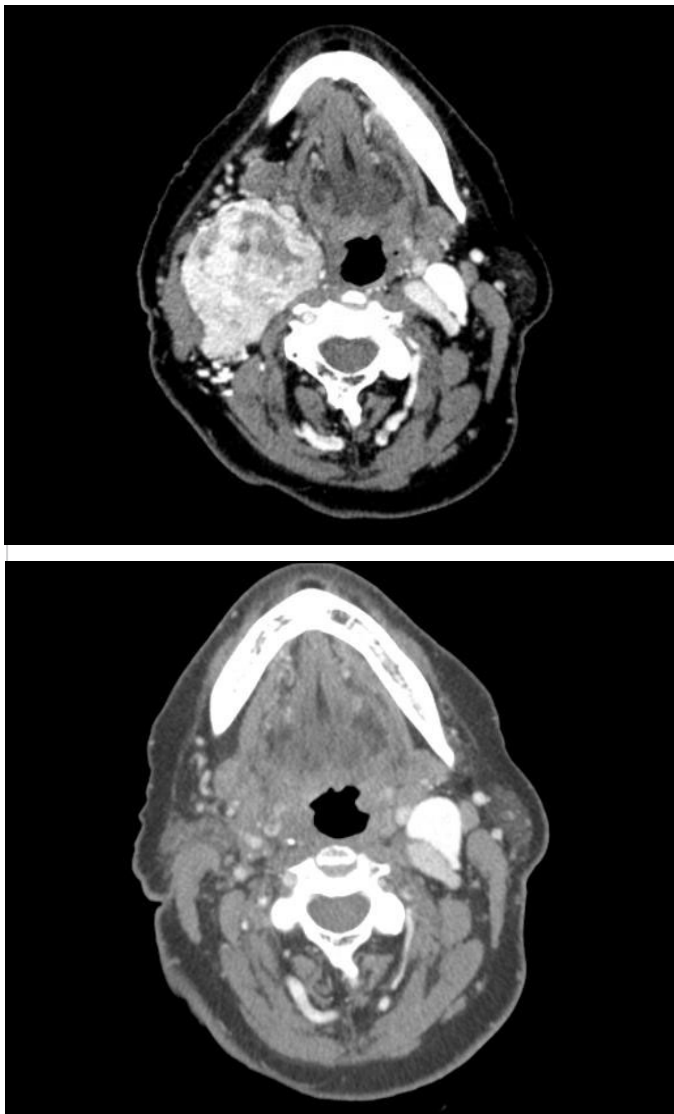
a. Preoperative contrast enhanced CT of the neck demonstrating right-sided Shamblin type III CBP of an 81-year-old female patient; b. Postoperative contrast enhanced CT of the neck
